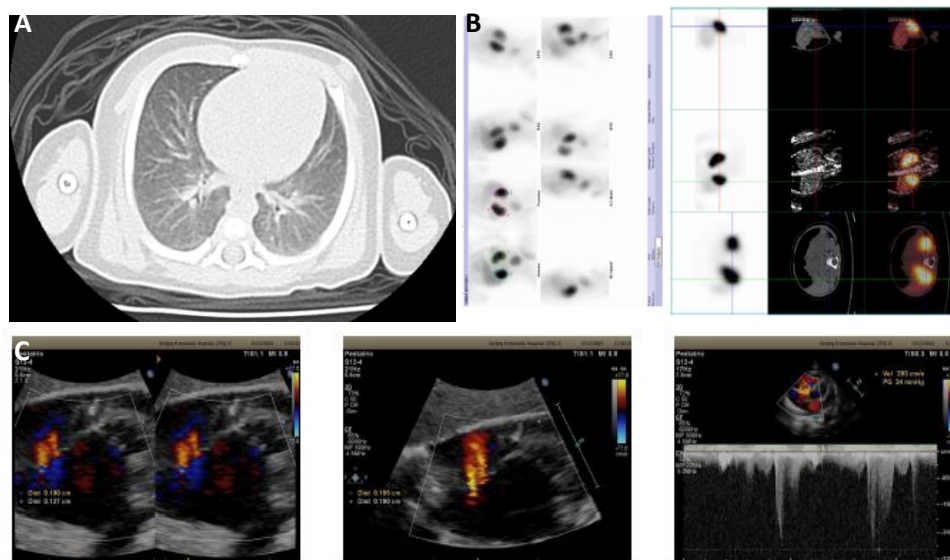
Chest CT indicating normal lungs, no candida lung infection (A). 99mTc-DMSA static renal imaging showing normal kidney without acute pyelonephritis or scar (B). Echocardiogram revealing a small atrial septal defect and patent foramen ovale (0.19 cm, 0.13 cm) without endocarditis (C).
